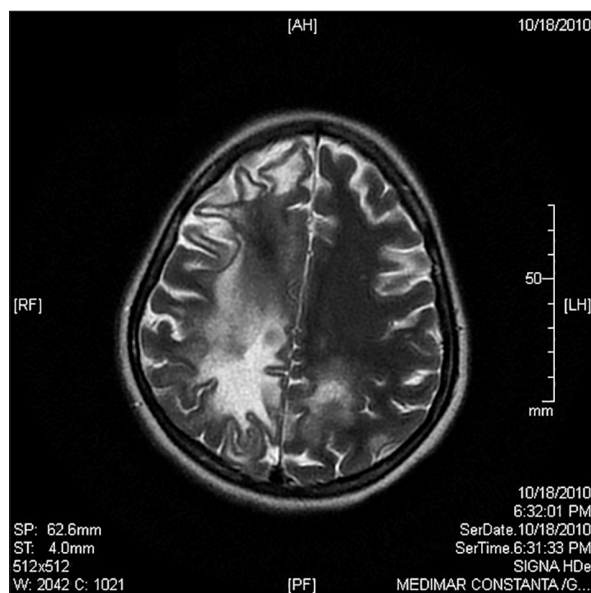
Cerebral MRI scan – hyperintense areas on axial T2 weighted images; the lesions are located predominantly right fronto-parietal, with no mass effect
